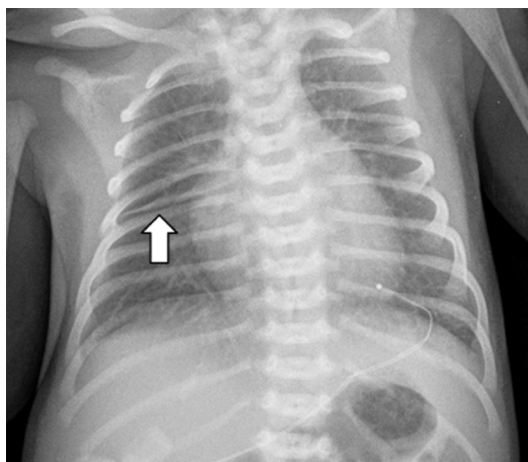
A 3-hour-old full-term boy born via cesarean section with transient tachypnea of newborn (TTN). Frontal chest radiograph demonstrates bilateral pulmonary interstitial opacities and trace fluid (arrow) in the minor fissure.
